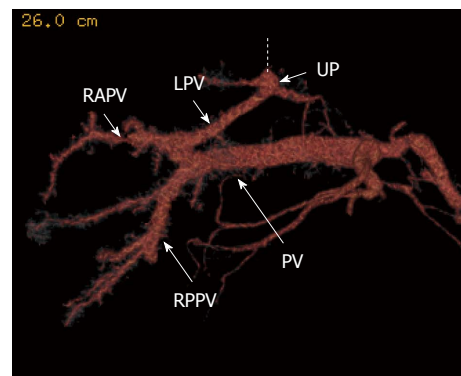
Computed tomography portography reveals the portal venous anomaly. The dotted line is the round ligament. PV: Portal vein; LPV: Left portal vein; RAPV: Right anterior portal vein; RPPV: Right posterior portal vein; UP: Umbilical portion.
